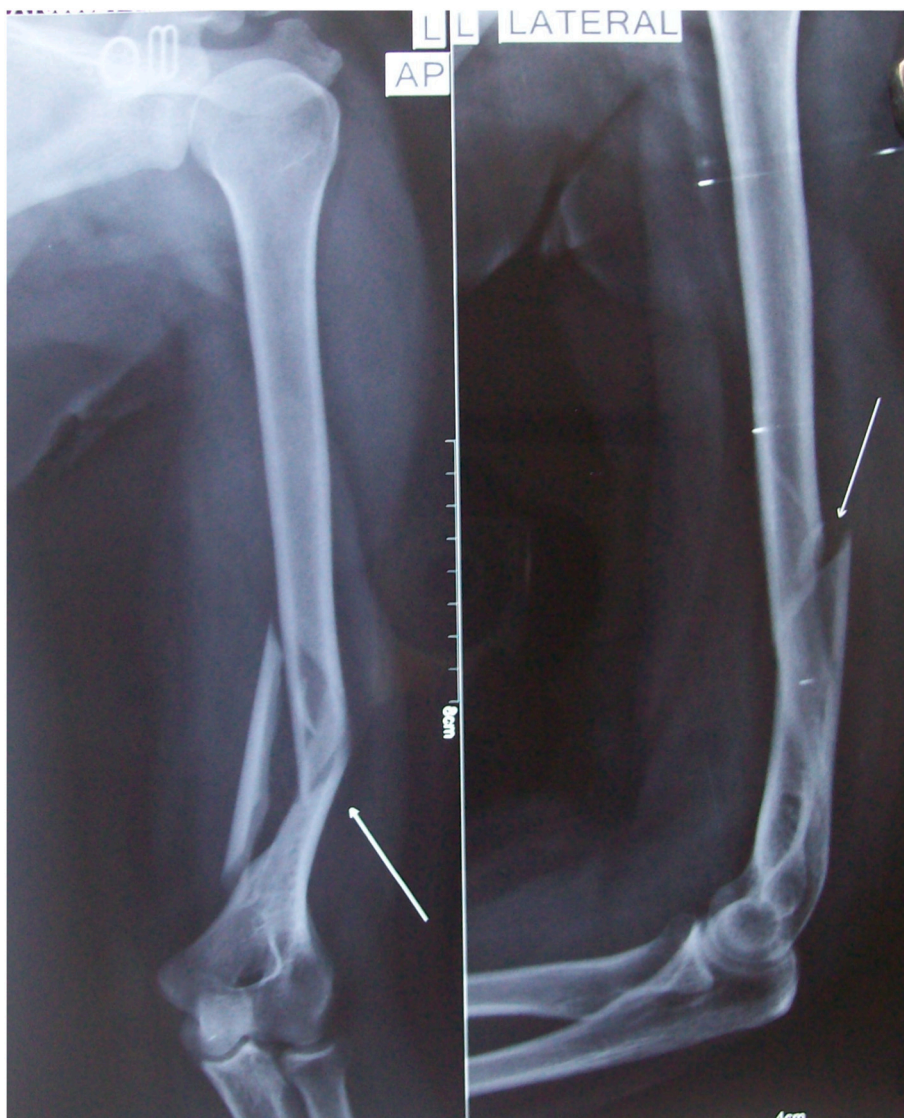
Preoperative radiographs of a 40-year-old male patient showing extra-articular distal-third diaphyseal fracture of left humerus (AO/OTA-12B1) without any intra-articular involvement.
